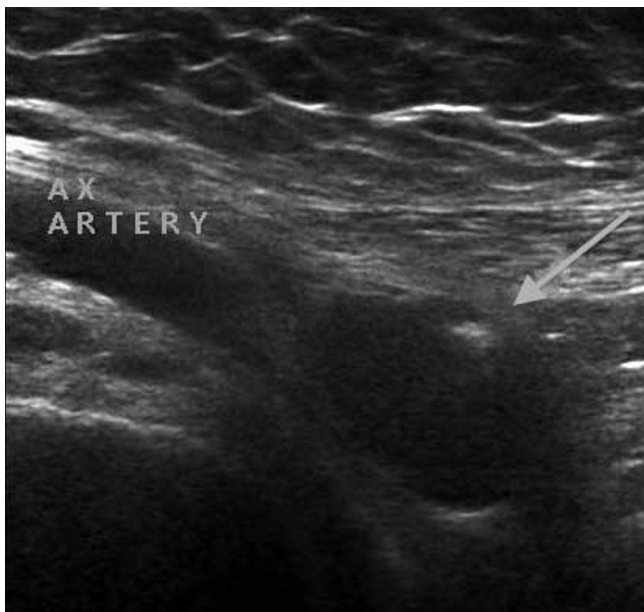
79-year-old woman with brachial plexus tumor. Longitudinal ultrasound shows the right axillary artery with the adjacent nerve-sheath tumor. Note the eccentric hyperechoic focus (arrow).
